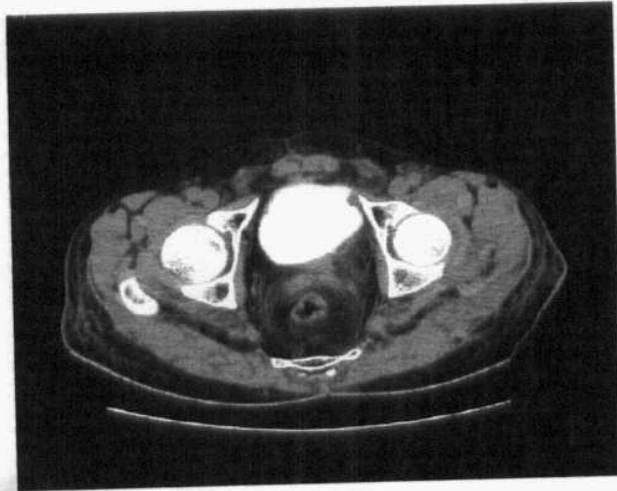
Axial CT with urografin contrast.
